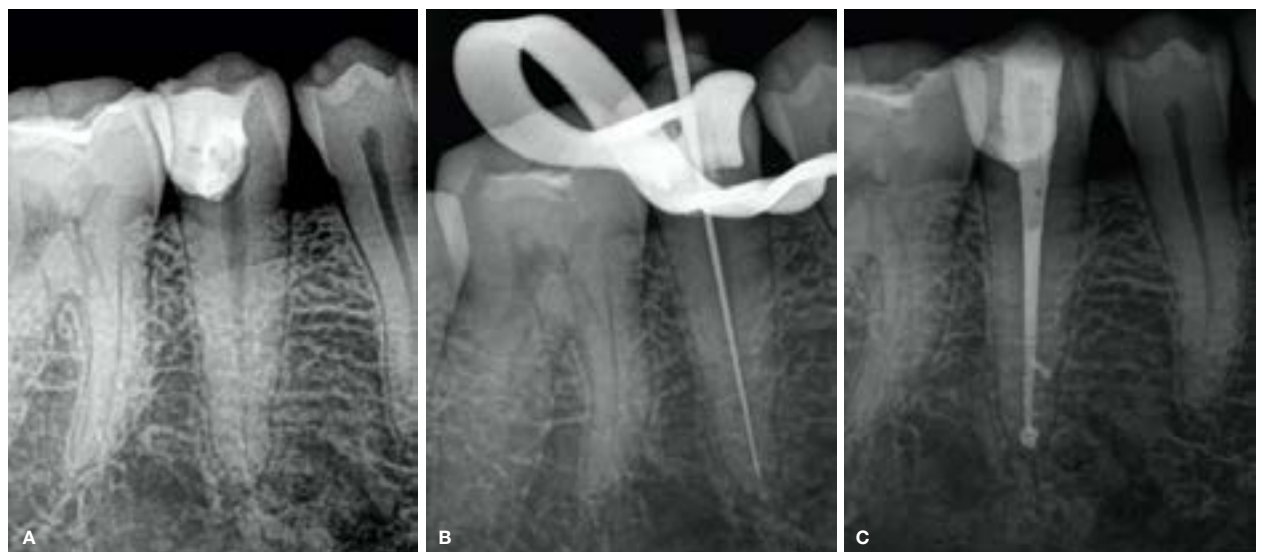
(A) Preoperative periapical radiograph of the mandibular right second premolar after a previous an emergency root canal treatment.
